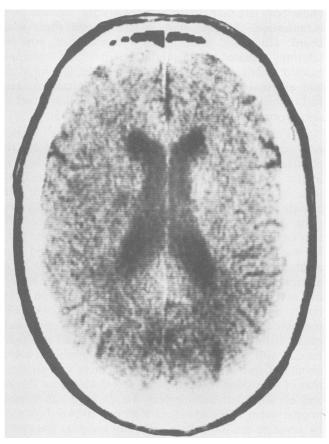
A computed tomographic scan showing a 1-cm ill-defined lucency in the right basal ganglia.
